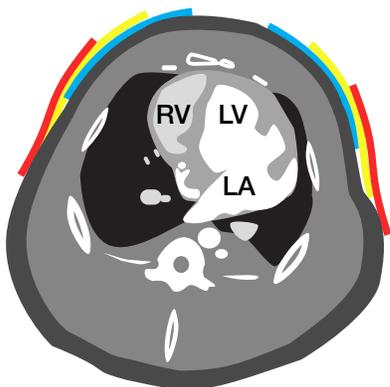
Axial view from CT scan of the thorax, with the right ventricle (RV), left ventricle (LV) and left atrium (LA) labeled. Radio-opaque markers were used to identify electrode pad locations.
